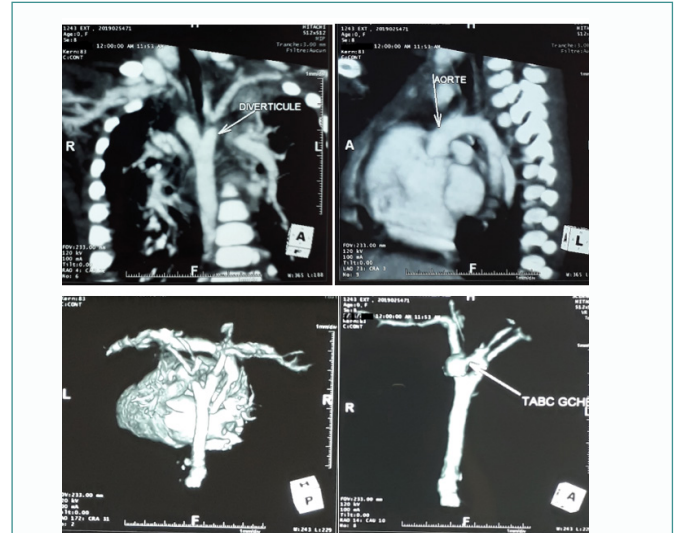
Thoracic CT angio showing a double aortic arch.
